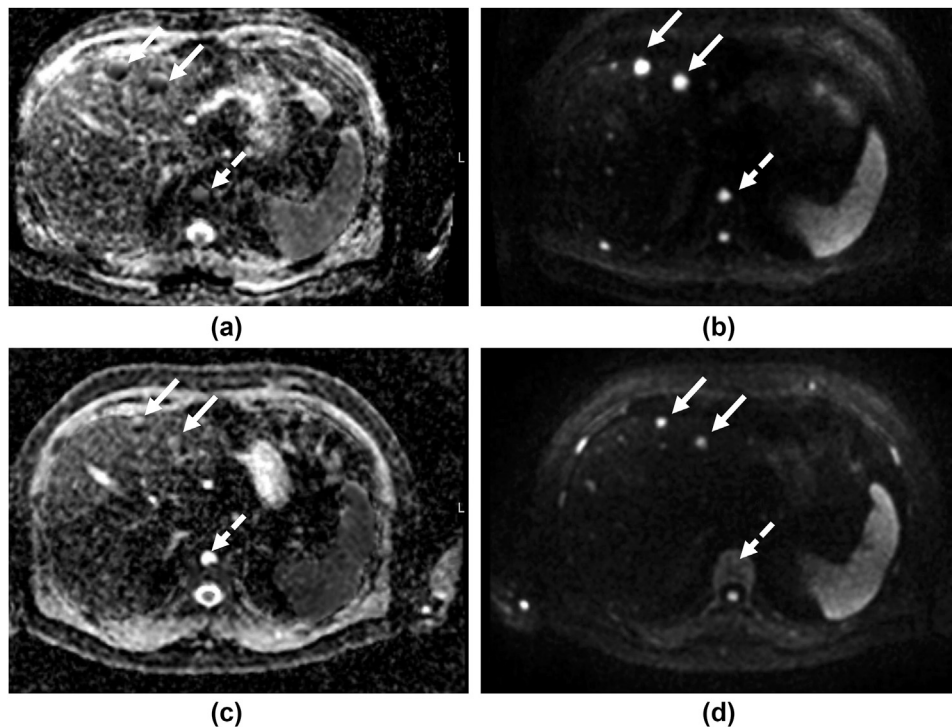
Hepatic and bone disease responding to 6 cycles of docetaxol treatment in a patient with advanced prostate cancer. (a,b) Axial ADC map and $b = 900 \text{ s/mm}^2$ DW-MRI before and (c,d) after 6 cycles of treatment demonstrates sites of disease in the liver (white arrows) and T11 (white dashed arrows). Following treatment, there is a decrease in size of the liver lesions and increase in ADC of the liver and bone lesions.
